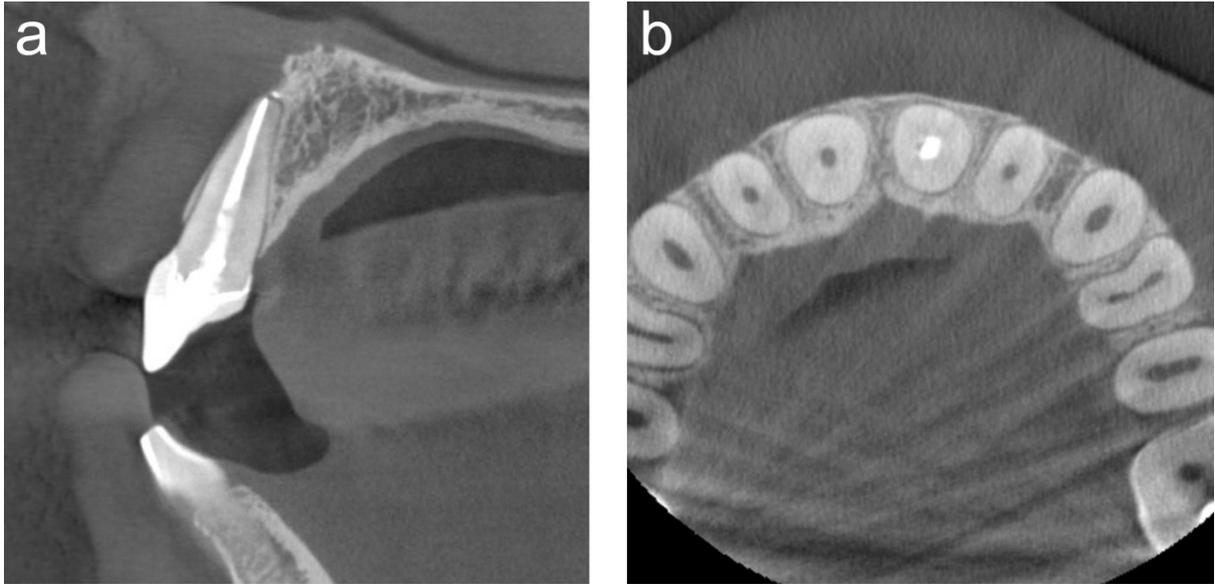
Baseline cone-beam computed tomography volume. 2a Parasagittal view through tooth #9. 2b Axial view.
